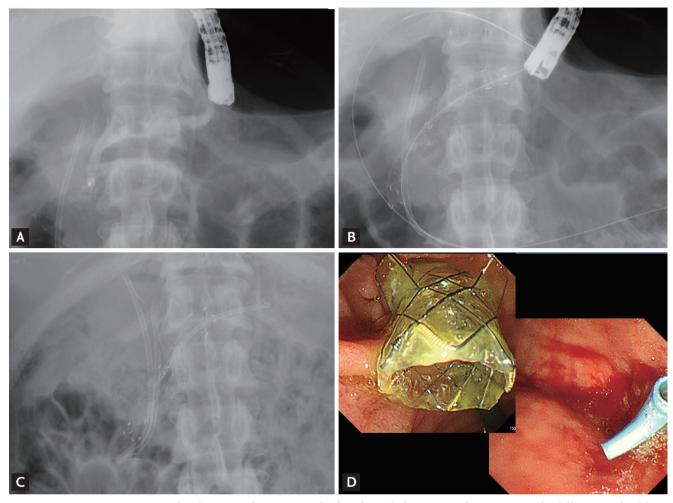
Representative case of endoscopic ultrasonography (EUS)-guided anterograde insertion of a fully covered self-expandable metal stent (FC-SEMS) for a stricture in the main pancreatic duct. (A) EUS-guided anterograde pancreatographic image showing dilation of the main pancreatic duct with a severe stricture at the head of the pancreas. (B) EUS-guided anterograde insertion of a FC-SEMS through the stricture of the main pancreatic duct. (C) Simple abdominal plain X-ray showing the fully expanded FC-SEMS in the main pancreatic duct and two plastic stents in the biliary and pancreatic ducts for internal drainage of pancreatic juice. (D) Endoscopic images showing the status of the end of the FC-SEMS at the ampulla and the end of the plastic stent in the body of the stomach.
